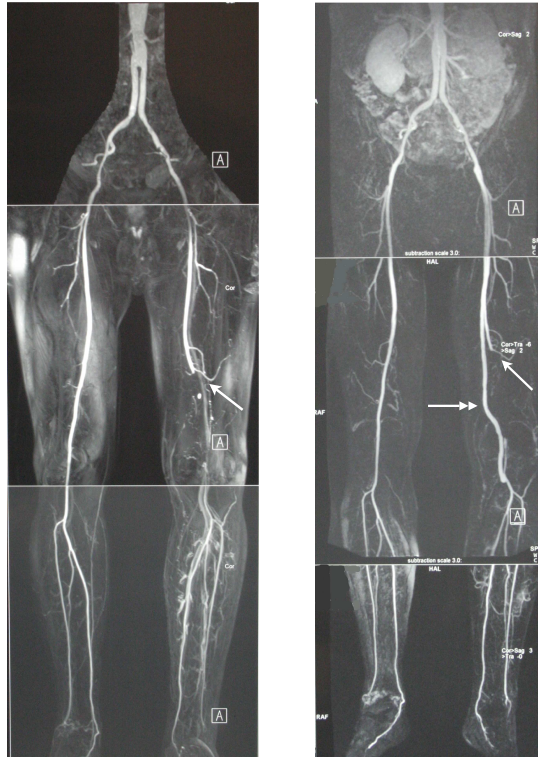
MRI images of the lower-limb arterial network of a patient before (left) and after (right) surgery. The occlusion of the superficial femoral artery is indicated by a simple arrow. After surgery, the bypass graft (reversed vein) is marked by a double arrow.
